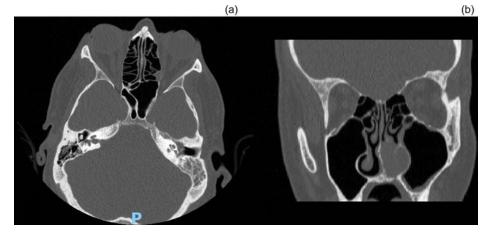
Computed tomography scans of the nose and paranasal sinuses: (a) left otitis media and mastoid air cell effusion, and (b) ill-defined soft tissue lesions of left nasal cavity. P = posterior
